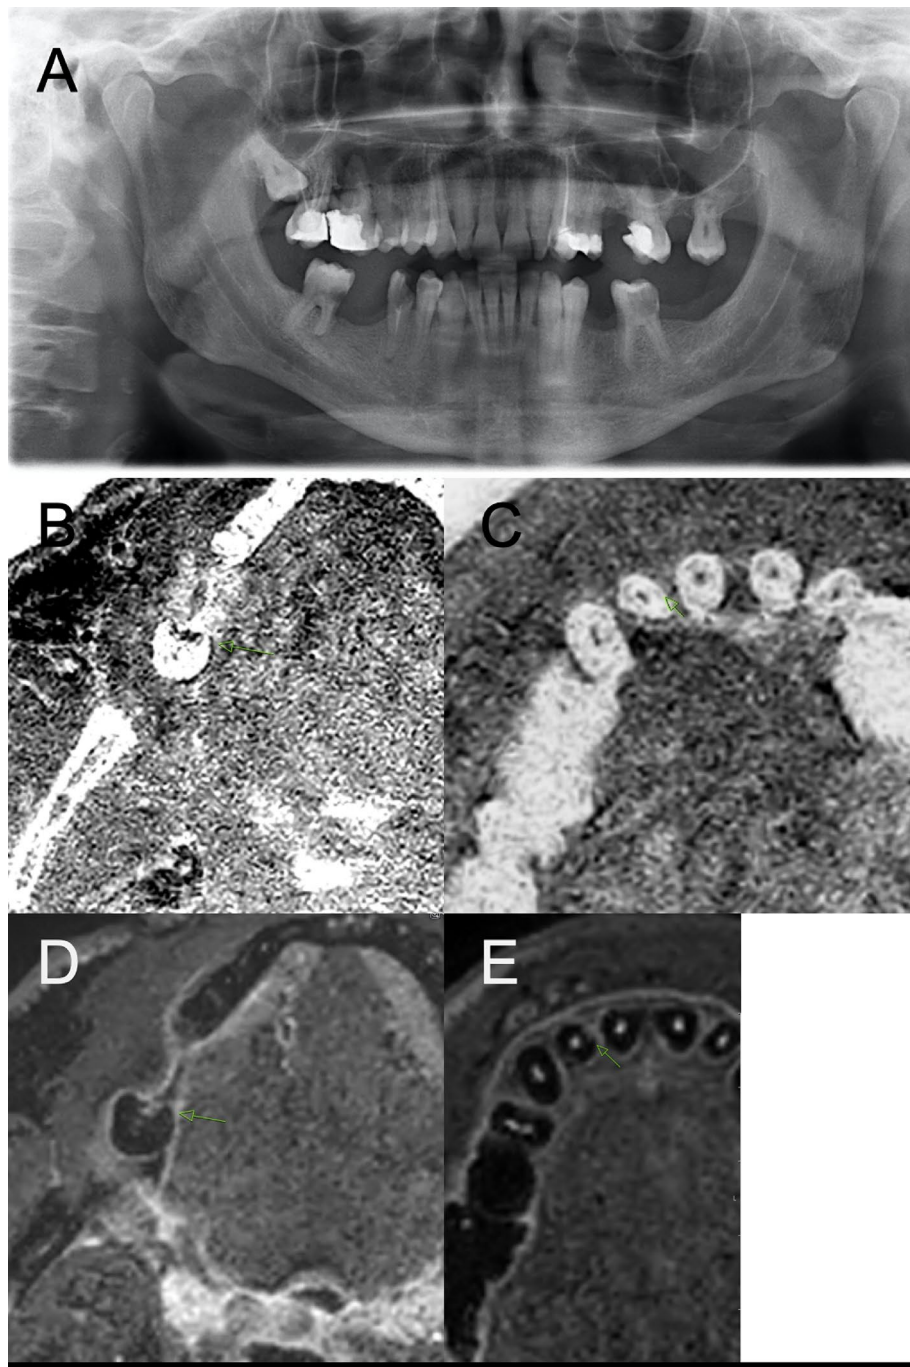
This figure shows a 40 years old male patients with multiple extensive carious lesions in the molar region of the mandible. (A) The OPT shows D4 carious lesions in the teeth 36 and 46 also detected clinically and verified by dental radiography (not shown). Also, a carious lesion can be detected in 44, which displayed only a subtle superficial lesion of the enamel but extensive destruction of the dentin. (B) In the T1 FFE sequence corresponding to the radiolucency a carious lesion is depicted in 46. (C) The STIR sequence also shows a localized hyperintensity with slightly minor dimension. With regard to the size of the carious lesion it can be assumed that only some areas maintain activity whereas some are already in an arrested state. (D) The 45° rotated tooth 12 shows no definite pathology neither in T1 based imaging nor in the OPT or clinical inspection. (E) In the STIR sequence a subtle localized hyperintensity is visualized in the mesial part of 12 and the gingival tissue between 11 and 12.
